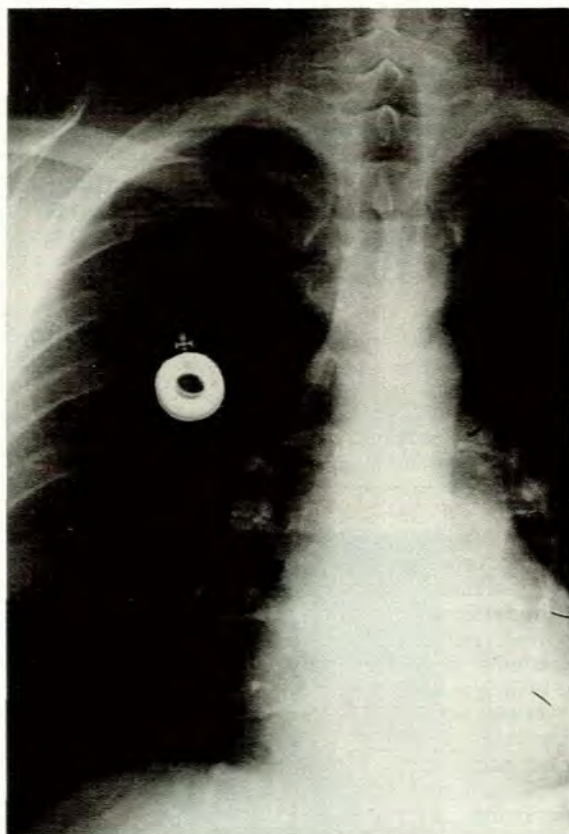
Radiograph of patient 9 showing the fracture site at the junction of the medial aspect of the first rib and the clavicle. The embolic distal segment can be seen in the lower right of the picture.
